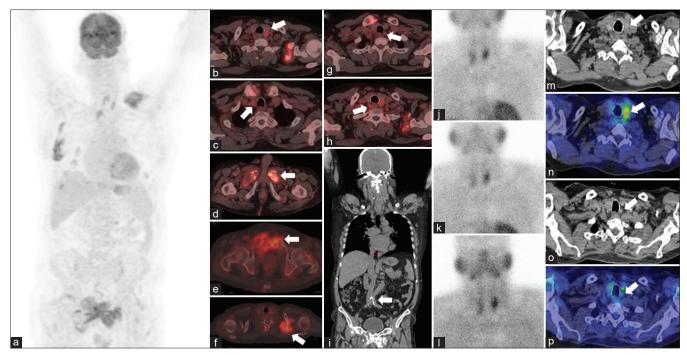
The maximum intensity projection (a) image of PET revealed metabolically active lesions in the left clavicular region and bilateral pelvic region. Axial fused PET/CT images (b, c, g and h) show metabolically active soft tissue density lesions in the left superior, left inferior, right superior, and right inferior parathyroid locations, respectively (white arrows). Axial fused PET/CT images (d-f) show calcific muscle deposits and metabolically active lesions in the medial end of the left clavicle and bilateral pelvic bones with soft tissue components (likely brown tumors) (white arrows). Coronal CT image (i) shows diffuse vascular calcification in multiple medium- and small-sized arteries (white arrow). Planar MIBI images (j-l) show bilateral parathyroid adenomas. Axial CT and fused SPECT/CT images (m-p) show left superior and inferior parathyroid adenomas. Axial CT and fused SPECT/CT images [m-p] show left superior and inferior parathyroid adenomas (white arrows). PET/CT: Positron emission tomography/computed tomography, SPECT: Single-photon emission computed tomography, MIBI: Methoxy-isobutyl-isonitrile
